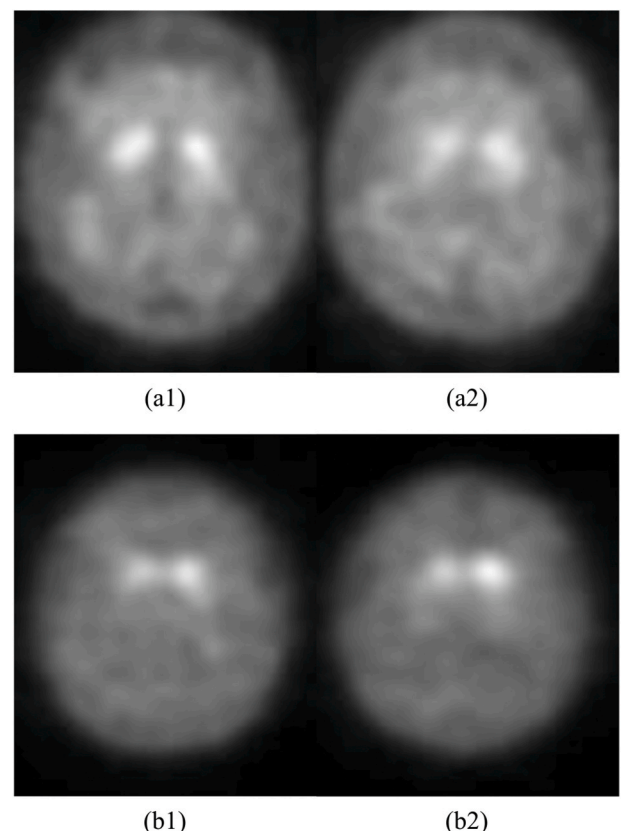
Example longitudinal DAT SPECT images of two patients (a, b) collected at year 0 (1) and year 1 (2).
